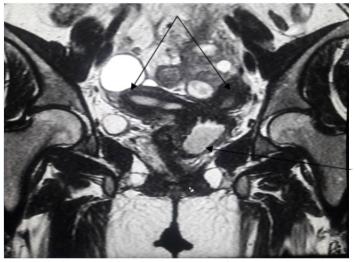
Coronal T2 weighted image of MRI scan showing two uteri and hematocolpos
